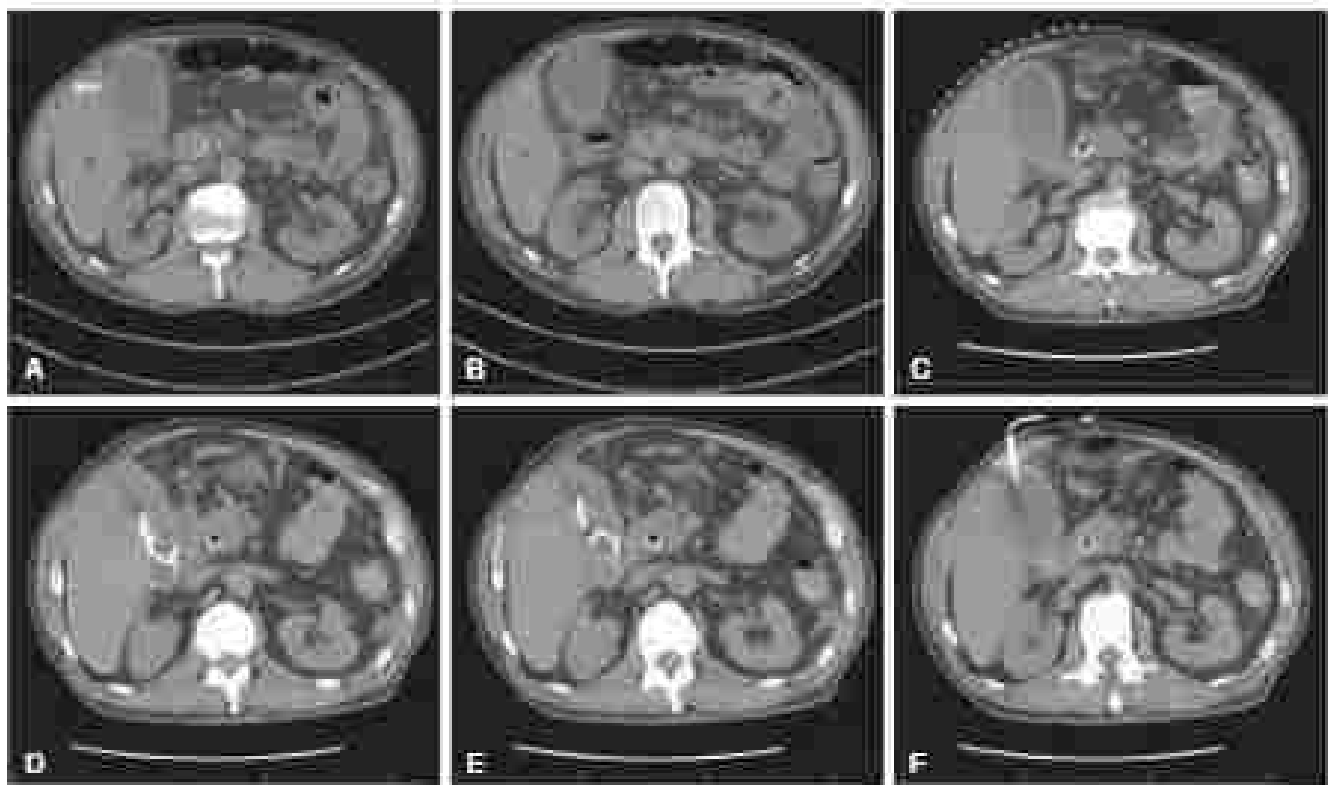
Computed tomography placement of cholecystostomy tube. (A–B) Catheter is resident. (C) Computed tomography markers placed on abdominal skin in right upper quadrant to help with gallbladder. (D–F) Definition of pigtail catheter placement in gallbladder lumen.
